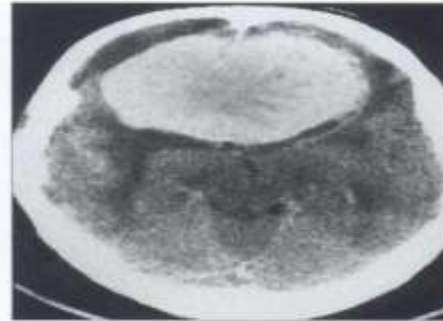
Contrast-enhanced CT scan of a typical benign meningioma.
